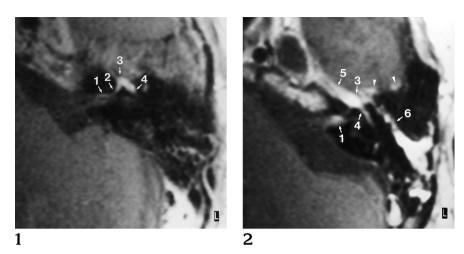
Contrast-enhanced transverse T1-weighted (560/16/4) MR image 142 days after delayed posttraumatic peripheral facial nerve palsy shows no visible fracture line. Minimal enhancement of the distal intrameatal segment (1), moderate enhancement of the labyrinthine segment (2), and intense enhancement and thickening of the geniculate ganglion (3) and proximal tympanic segment (4) are related to long-lasting damage of the blood/ peripheral nerve barrier and formation of perineural fibrosis in the region of the geniculate ganglion.
